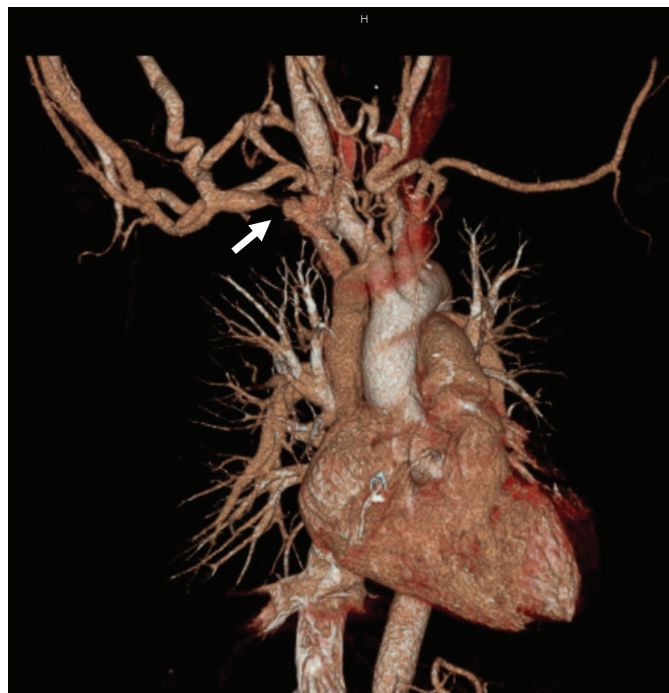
Computed tomography venography (CTV) of patients in figure 14-3 showing right subclavian vein occlusion (white arrow).
